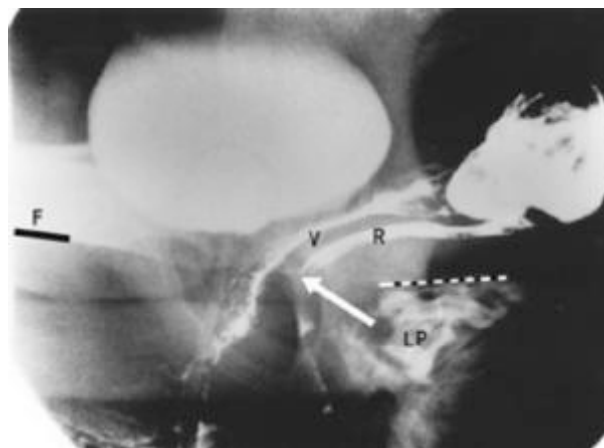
“Squeezing” X-ray, sitting position. With reference to “F”, lower border of femur, bladder, proximal vagina (V) and rectum (R) are stretched upwards and forwards. Note horizontal position of levator plate (LP).
